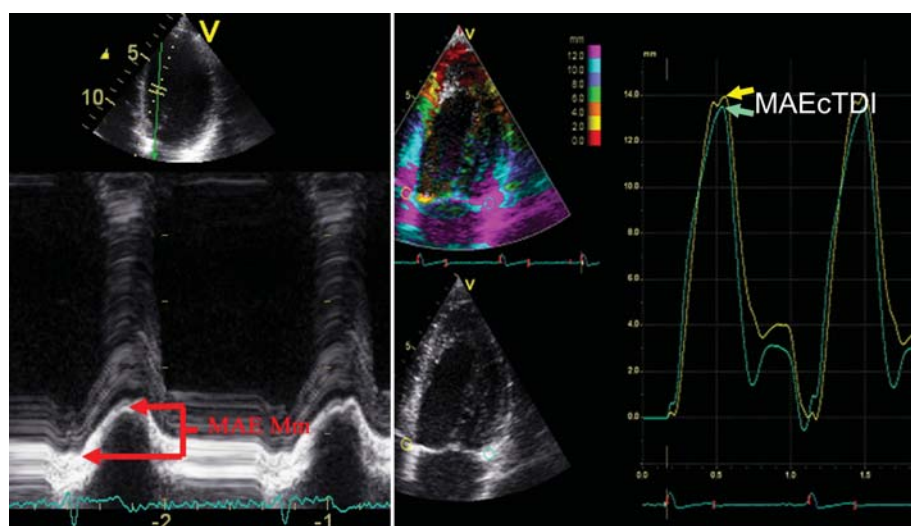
Measurements of systolic mitral annular excursion (MAE) obtained by two different methods in four-chamber view. To the left, systolic MAE is measured by reconstructed M-mode (Mm). To the right, MAE is measured at the top of the displacement curve obtained from integrated velocity colour tissue Doppler imaging (cTDI) recordings.
